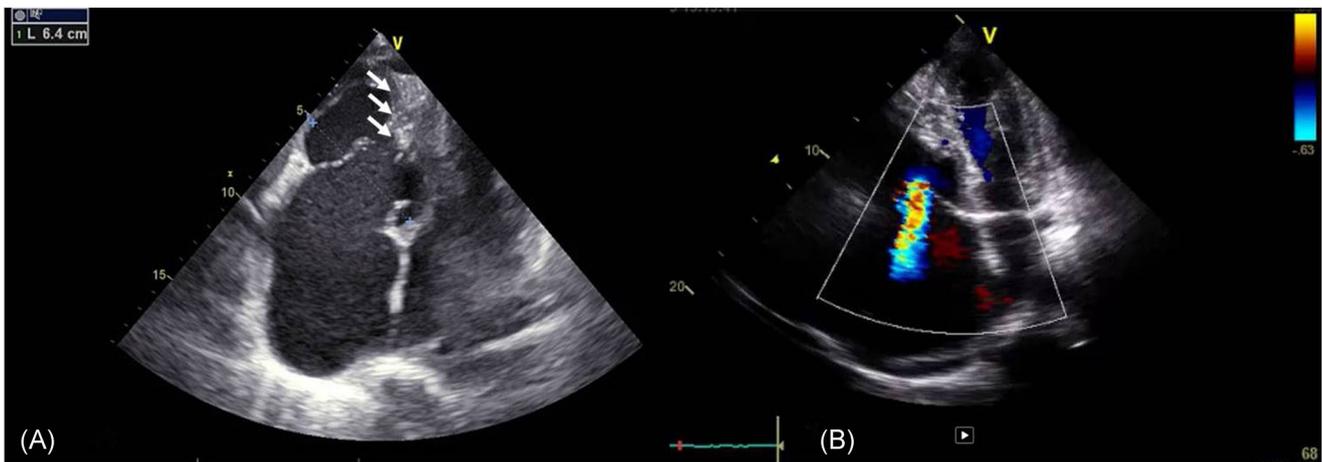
Panel A, Transthoracic echocardiography shows the partial obliteration of the RV apex (white arrows) and the severe RV dilatation (RV basal diameter 6.4 cm). Panel B, Transthoracic echocardiography shows severe tricuspid regurgitation due to failure of tricuspid leaflet coaptation
